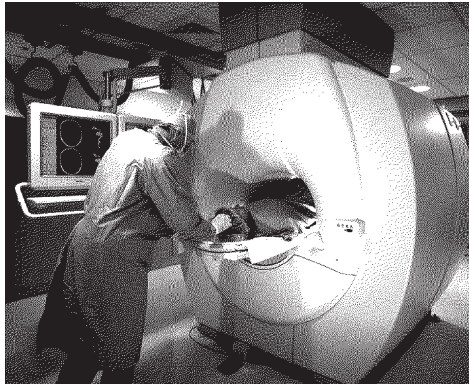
Example of an interventional procedure guided by MRI (neuro-imaging).
